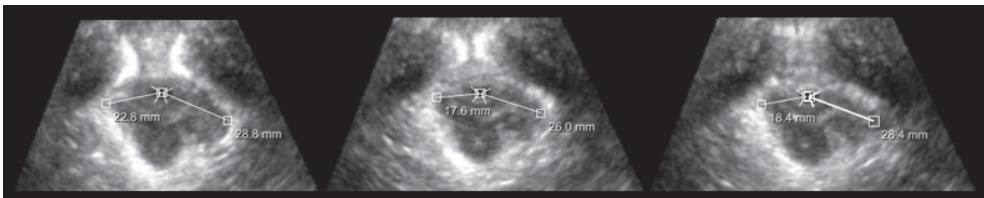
Transperineal ultrasound of a woman with complete unilateral avulsion showing the three central slices. On one side the levator-urethra gap is <25 mm (i.e., intact), whereas on the other side it is ≥25 mm (i.e., complete avulsion)
